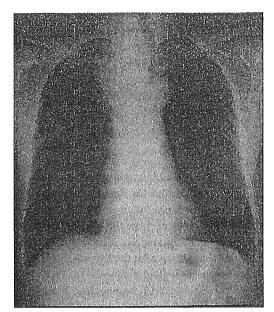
Chest X-ray showing a right upper mediastinal mass with a shift of the trachea to the left.
